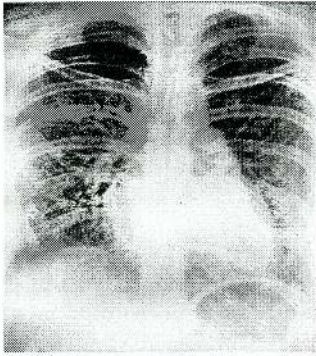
Chest X-ray shows an increased cardiothoracic ratio with a mild globular-shaped heart but no significant carinal widening. This appearance is suggestive of the pericardial effusion
